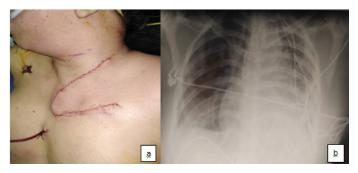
(a) Post-operative scar. (b) Post-operative chest X-ray showing a good reexpansion of the lung. can help differentiate between these tumors [4].
